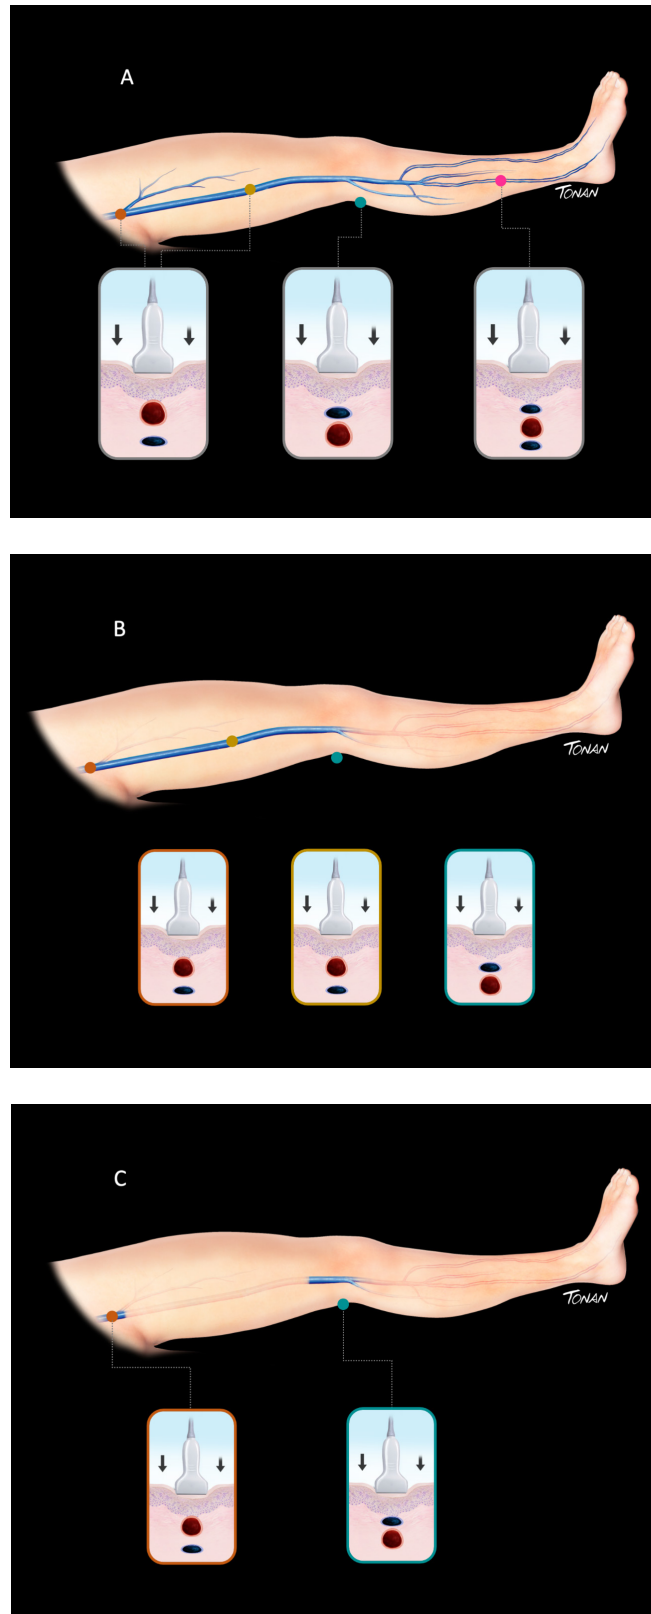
A: complete lower extremity venous compression ultrasound protocol; B: three-point extended compression ultrasound protocol; C: two-point extended compression ultrasound protocol.
